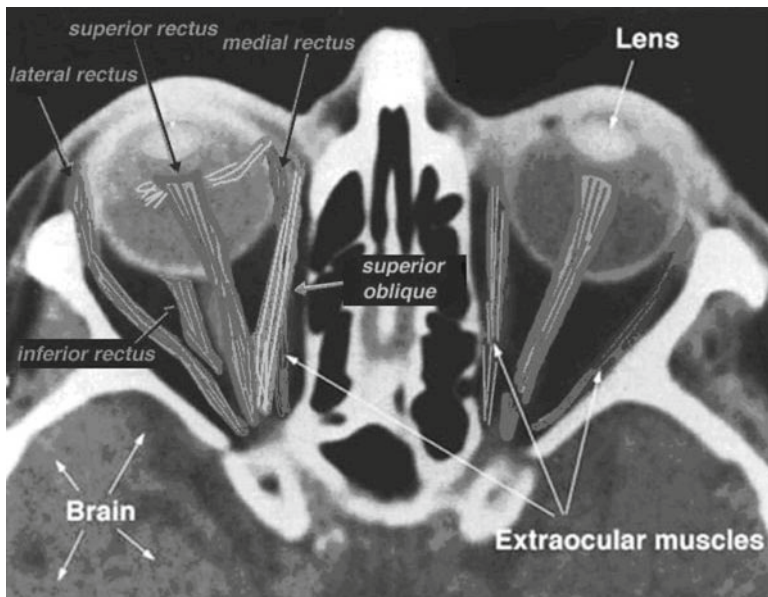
Horizontal transverse CT scan at the plane of the brain and orbits
